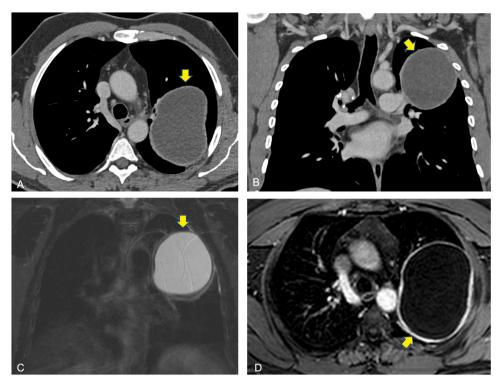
Axial and coronal contrast enhanced computed tomography images (A and B, respectively) well demonstrating the large hypodense lesion in the upper left lobe (yellow arrows) with a smooth and thick wall. The subsequent magnetic resonance (yellow arrows on the corona T2 weighted fat-sat and axial T1weighted fat-sat axial image after contrast injection in C and D, respectively) confirmed the fluid content of the lesion and nicely showed the contrast enhancement of the walls.
